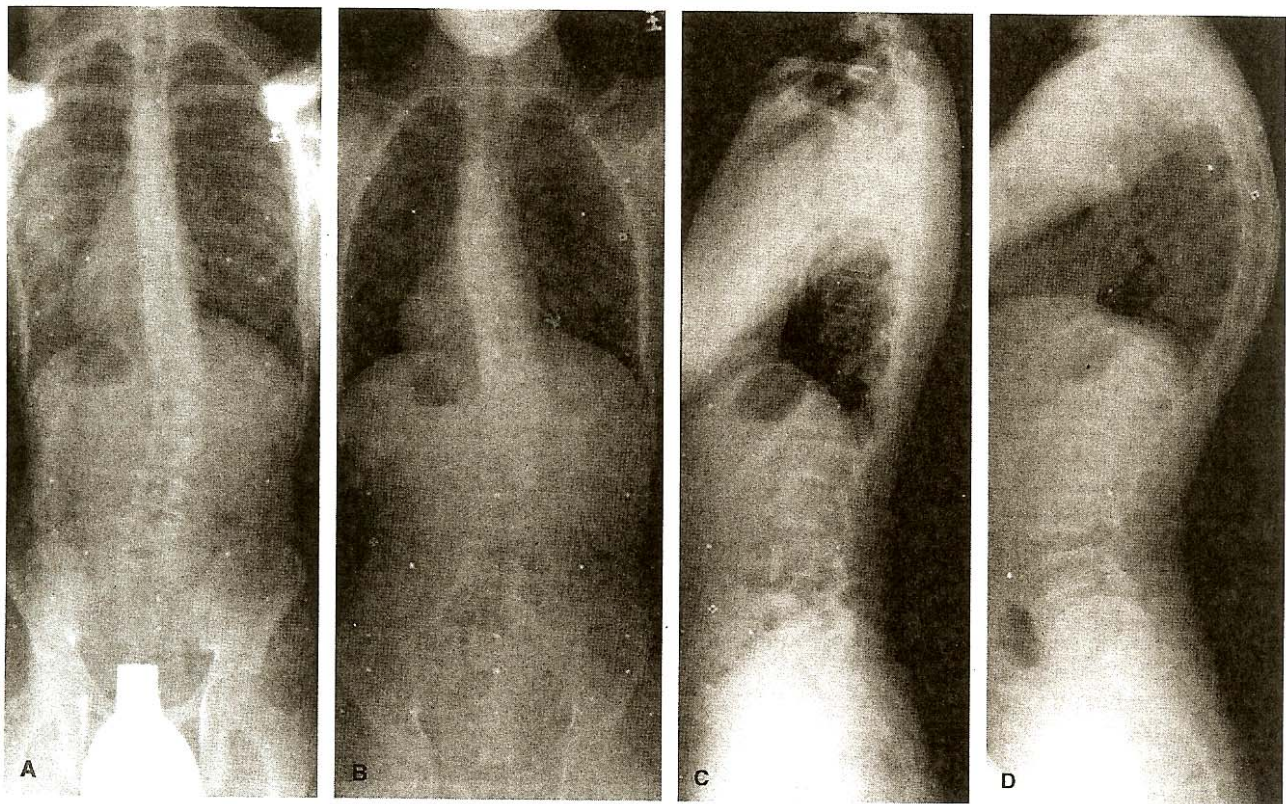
A-B: Posteroanterior radiographs of two different patients showing similar scoliosis curvatures: right thoracolumbar with an apex at T12 and 25° Cobb angle. C-D: Lateral radiographs of the same two patients, showing different sagittal curvatures: kyphosis of 22° and lordosis of 28° (C) and kyphosis of 69° and lordosis of 68° (D).
